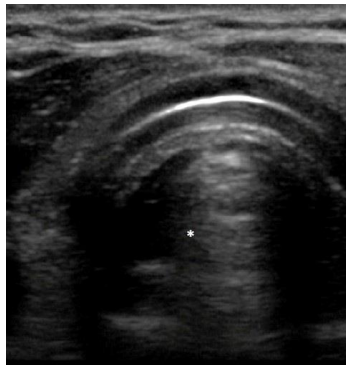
Short axis neck ultrasound from a healthy individual.
